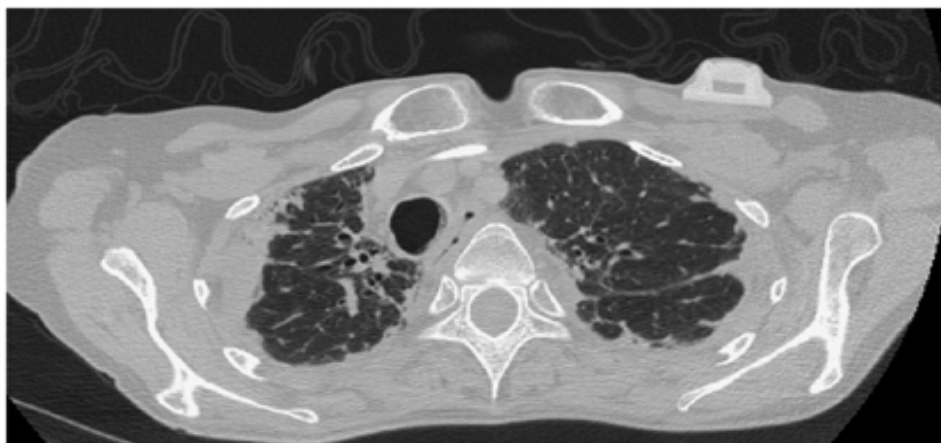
Chest CT of a PPFE study-patient.
